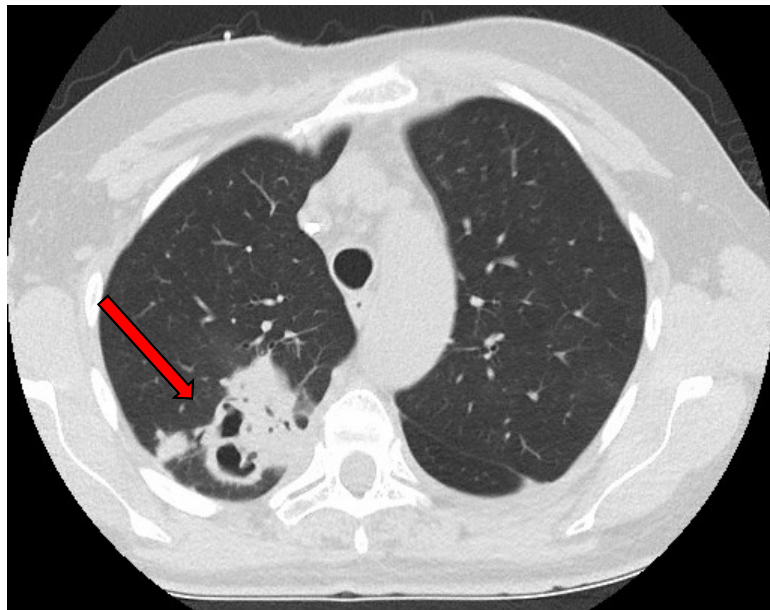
CT findings in a patient with a manifest pulmonary Nocardiosis at the Medical University of Graz. The red arrow points at a cavernous lesion. A nodular formation is located right by the cavern.
